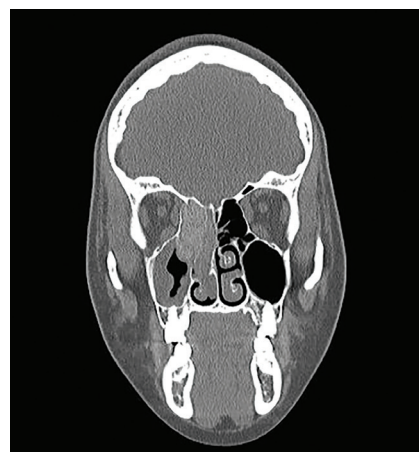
Coronal-view maxillofacial CT image without contrast showing expansive hyperdense material filling the paranasal sinuses, as well as erosion of bone walls.
